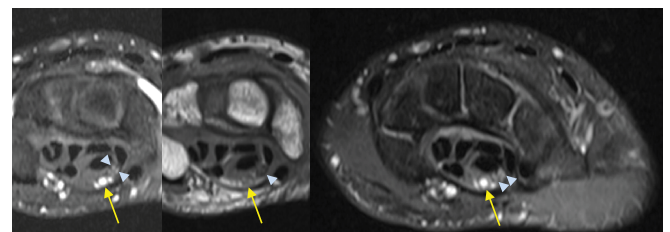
Axial T1-weighted and T2-weighted fat-suppressed MR images demonstrate the bifid median nerve (arrowheads) and persistent median artery (arrows) proximal to and within the carpal tunnel. The persistent median artery is positioned medial to the two branches of the bifid median nerve, consistent with a Type I configuration.
